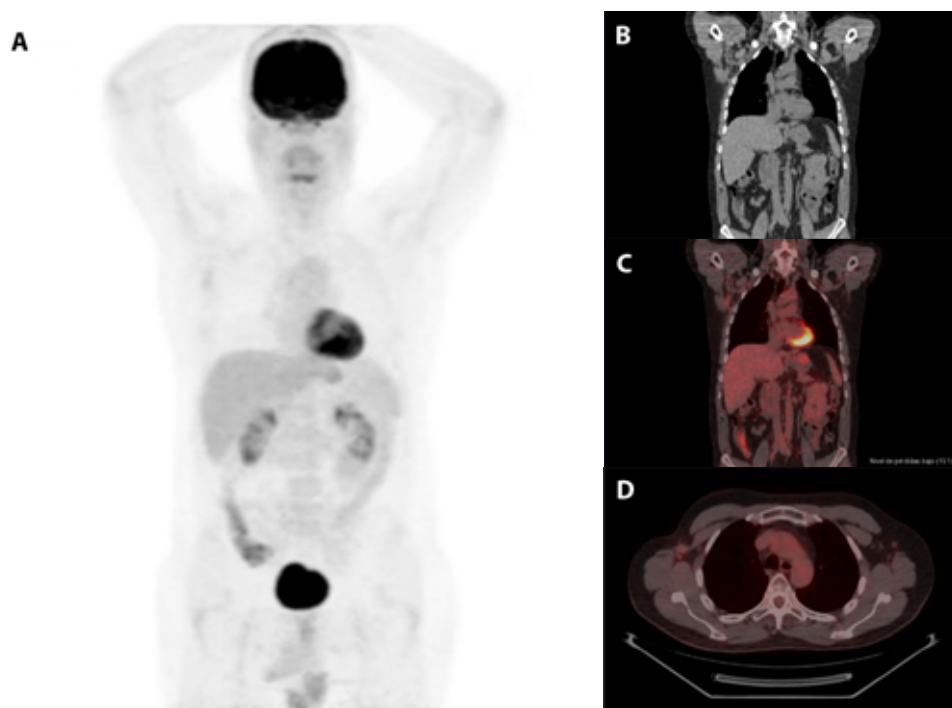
(A-D) 4-month control ^{18}F -FDG-PET/TC, September 2021: normalization of hypermetabolic lymphadenopathies in the left axillary region: resolution of the pathologic nodal uptake.
